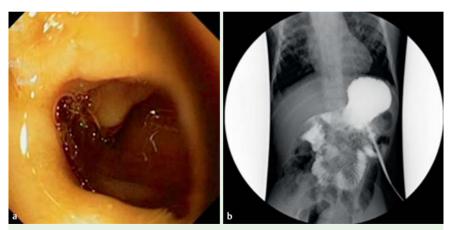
a Endoscopic view after resection. b Contrast radiograph after web resection.
